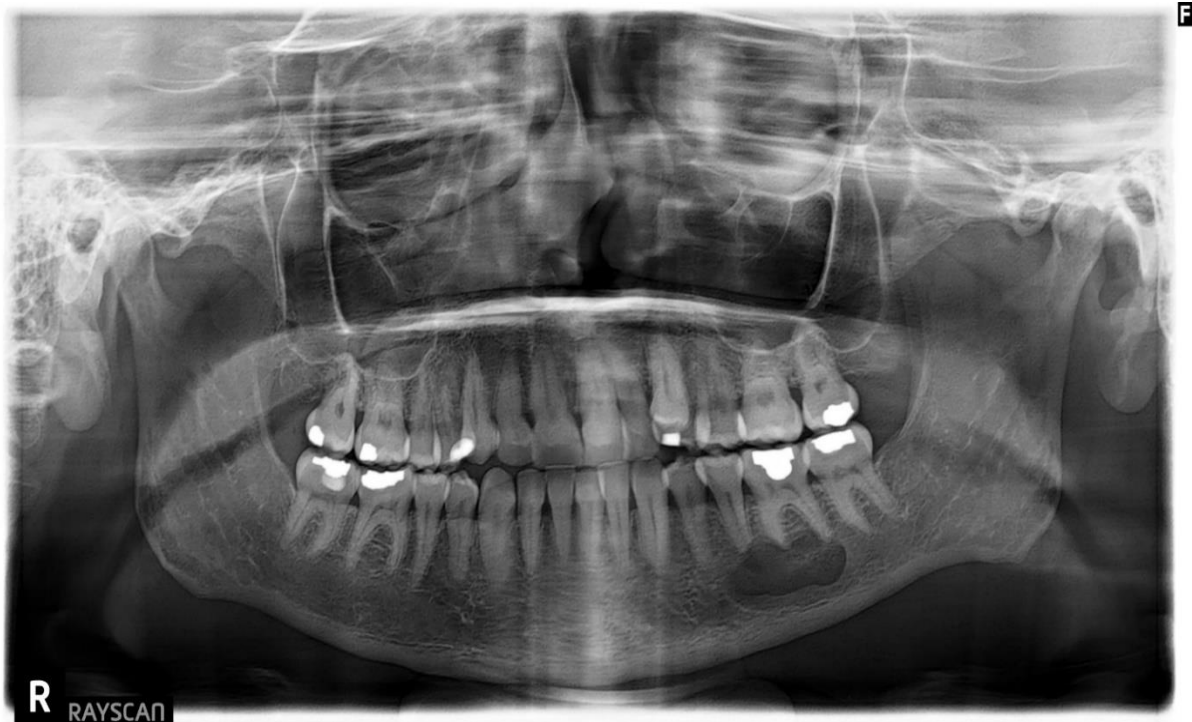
Panoramic radiograph 1-week post-op.
